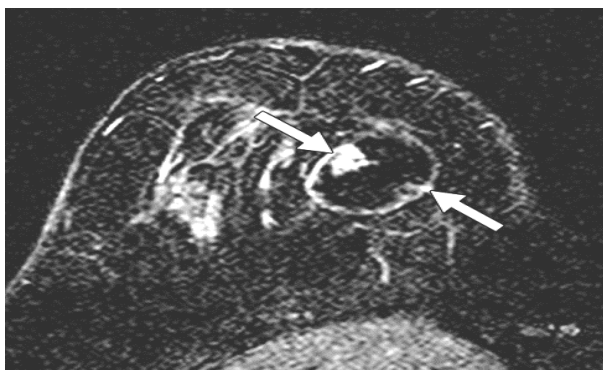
On MRI, the lesion was hyperintense on T2WI, hypointense on T1WI and showed Heterogenous enhancement on post contrast.
